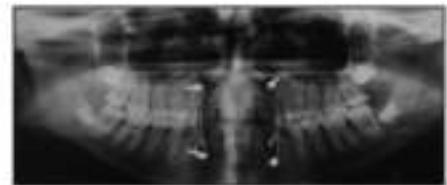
Intra Operative Orthopantomogram.
